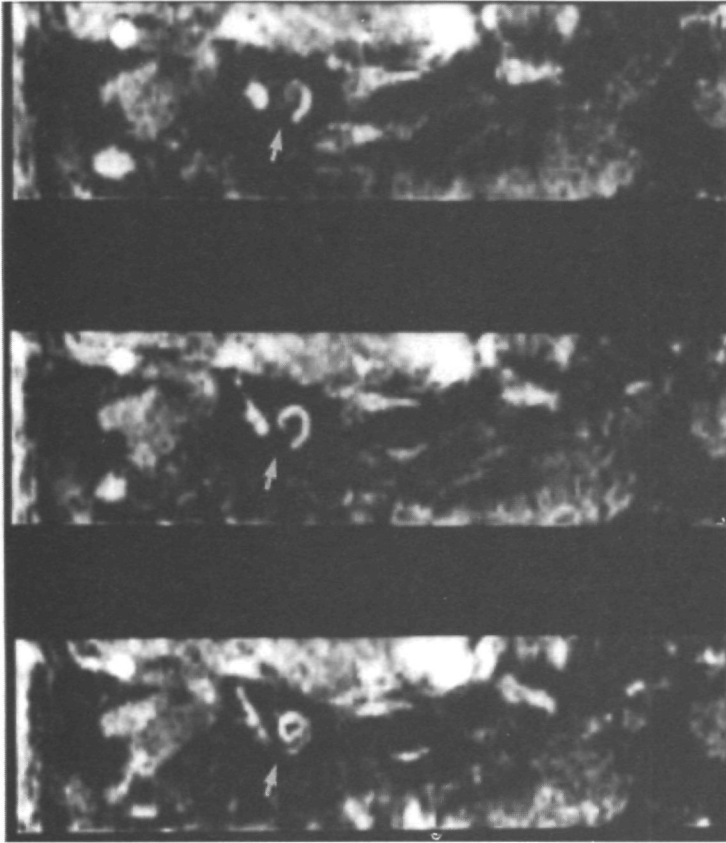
HRCT of both ears after mastoidectomy. Bilateral fenestral and retrofenestral otosclerosis. The double ring sign is demonstrated (arrows). Ill defined basal turn of the cochlea although a lumen remains visible.
